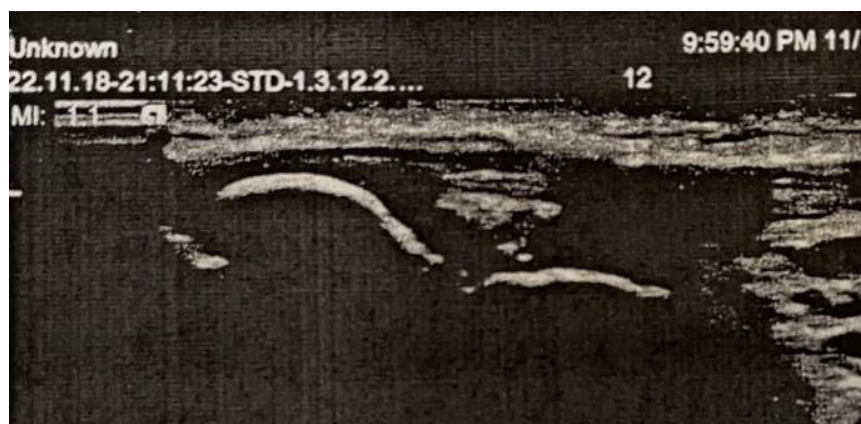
Ultrasound of the right knee. Boy, 17 years old. Multiple femoral and tibial FCDs. Osteochondropathy of the right tibial tubercle (Osgood-Schlatter disease)
